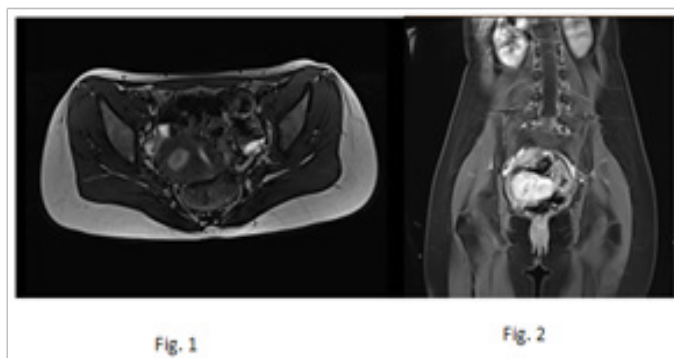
Preoperative MRI.
